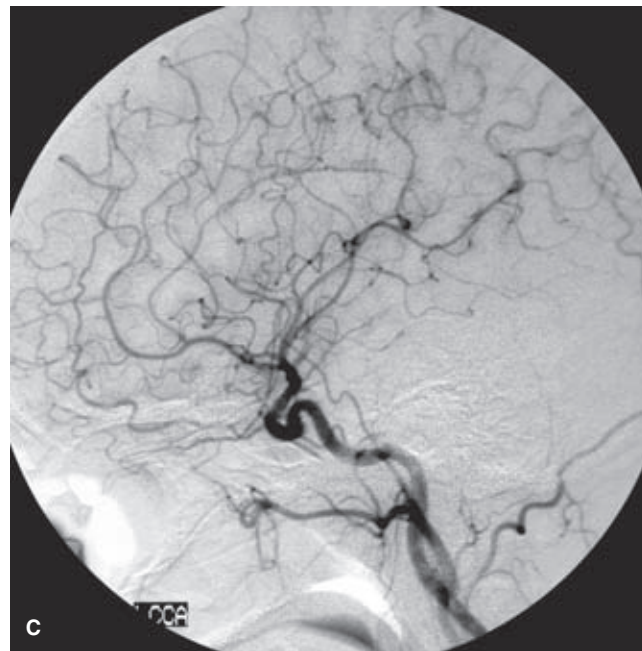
(CONTINUED) The arterial phase (C) is normal, with no evidence of early venous opacification or abnormal shunting. The parenchymal and venous phases (D) show gradual appearance of a patchy vascular structure in the left Sylvian region, which becomes more opacified with time (*arrows* in D) and drains eventually via anomalous medullary veins (*arrowheads* in D). The most likely diagnosis is an anomaly of venous drainage that has incorporated some element of pial veins into its structure. The long-standing nature of the lesion is suggested by the relative hypoplasia of the opercular structures on the CT and MRI. No treatment is warranted in a case like this. In fact, surgical removal or tinkering with these veins would likely induce venous infarction of normal tissue in the dominant hemisphere.
